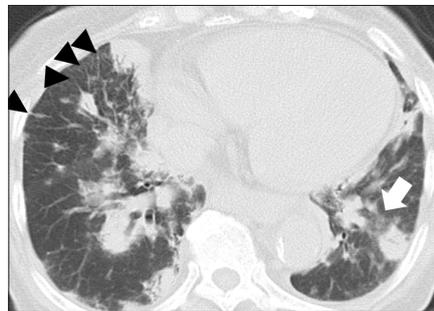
A 79-year-old woman with acute ATL. Chest CT demonstrates multiple consolidations and nodules. Interlobular septal thickening (arrowheads) and partial ground-glass attenuation (arrow) are also shown in the lung. The patient was diagnosed with ATL by sputum cytology.
